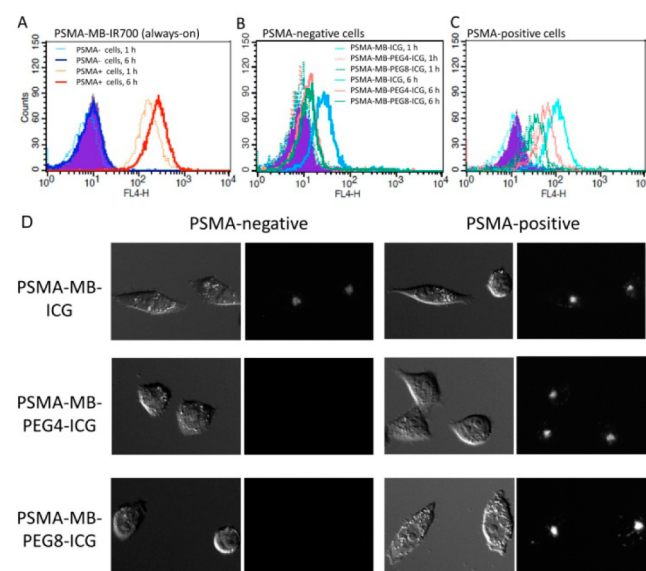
(A) Always-on probe, PSMA-MB-IR700, shows specific binding to PSMA-positive cells at 1 and 6 h after coincubation. Results for PSMA-negative (B) and positive (C) cell lines at 1 or 6 h after incubation with PSMA-MB-ICG, PSMA-MB-PEG4-ICG, and PSMA-MB-PEG8-ICG also show binding affinity to PSMA-positive cells and dequenching. Nonspecific binding is shown with PSMA-MB-ICG, suggesting free ICG formation. (D) PSMA-positive and -negative cells were incubated with PSMA-MB-ICG, PSMA-MB-PEG4-ICG, and PSMA-MB-PEG8-ICG for 6 h.
